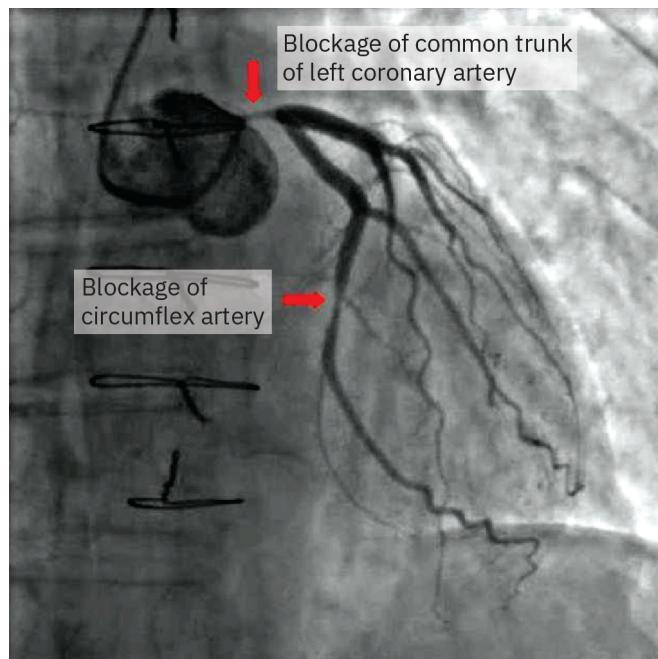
This coronary angiogram (a type of x-ray) shows a stenosis (blockage) in two different arteries. (credit: modification of work by Pantaleo, M.A., Mandrioli, A., Saponara, M. et al. “Development of coronary artery stenosis in a patient with metastatic renal cell carcinoma treated with sorafenib.” BMC Cancer 12, 231 [2012]. <https://doi.org/10.1186/1471-2407-12-231>; CC BY 2.0)
